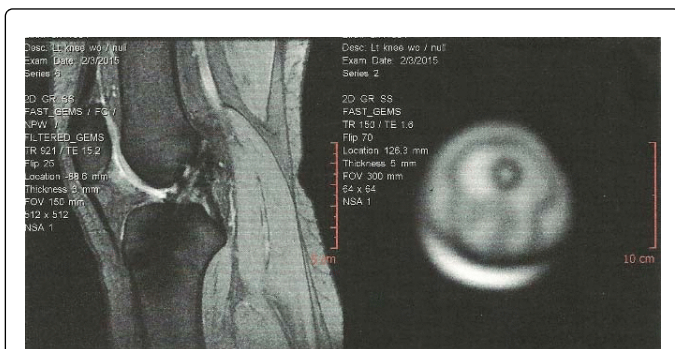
Post-op MRI at three months showing increased dark signal compatible with early vascularization and maturation of the autograft.
